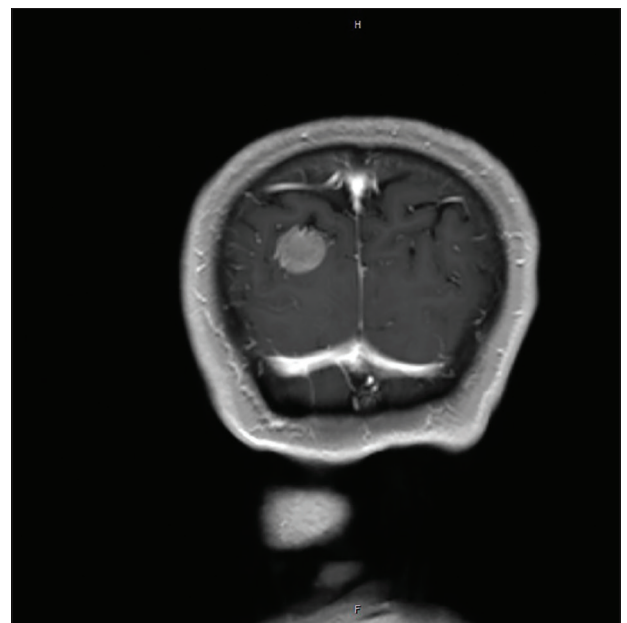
Magnetic resonance imaging (MRI) scan of the brain shows a parietooccipital mass.
